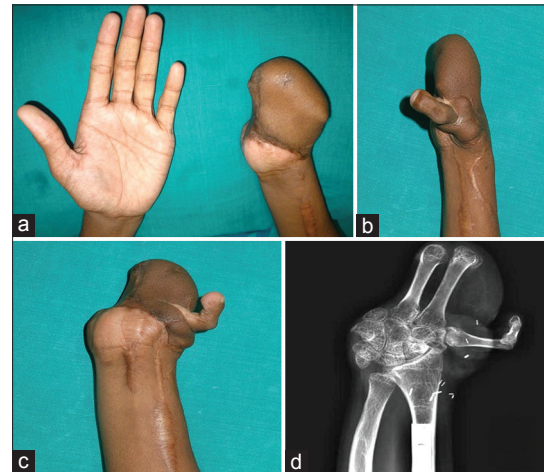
Patient 11, type 2D metacarpal hand. (a) Both hands, prior to toe transfer, showing hypogastric flap cover to left hand (b) Left hand following 2nd toe transfer to the thumb position, showing maximum span and (c) attempting full opposition. (d) Oblique radiograph 31 months following toe transfer showing bony union
